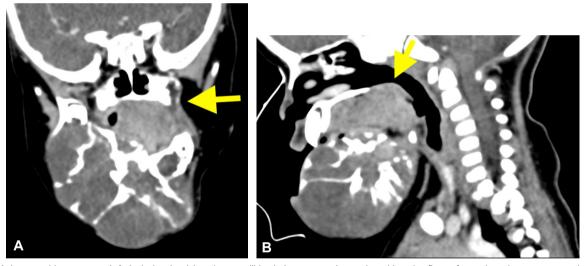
A large multiseptate cystic/lytic lesion involving the mandible. It is compressing and pushing the floor of mouth and tongue upward against hard and soft palate, thereby causing oropharyngeal compromise. (yellow arrows) A) coronal and B) sagittal sections of contrast enhanced computed tomography image
